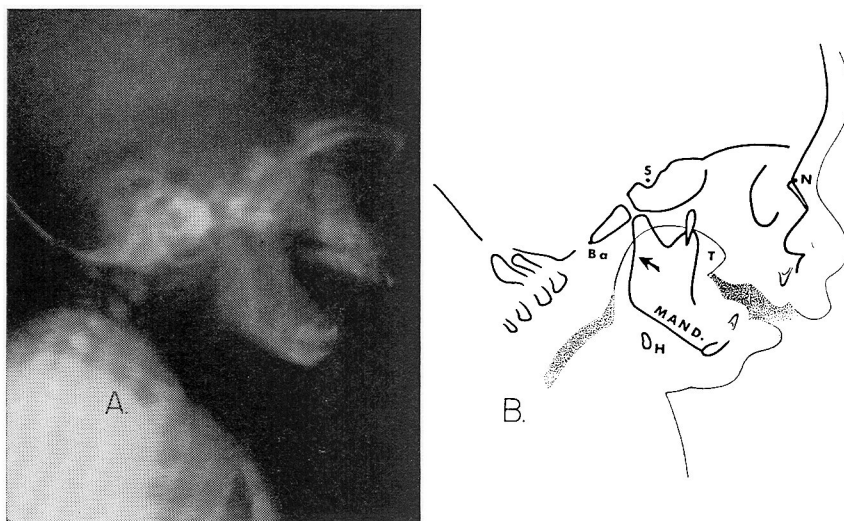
A (left), roentgenogram of T. E. taken in spine position. B (right), the tracing of the roentgenogram. Landmarks are: Nasion (N), Center of Sella turcica (S), Basion (Ba), Mandible (Mand), and Hyoid (H). Note hypoplastic mandible. The tip of the tongue is displaced dorsally and the tongue is obstructing the pharynx. The extent of glossoptosis is far greater than one would expect from this degree of micrognathia.
